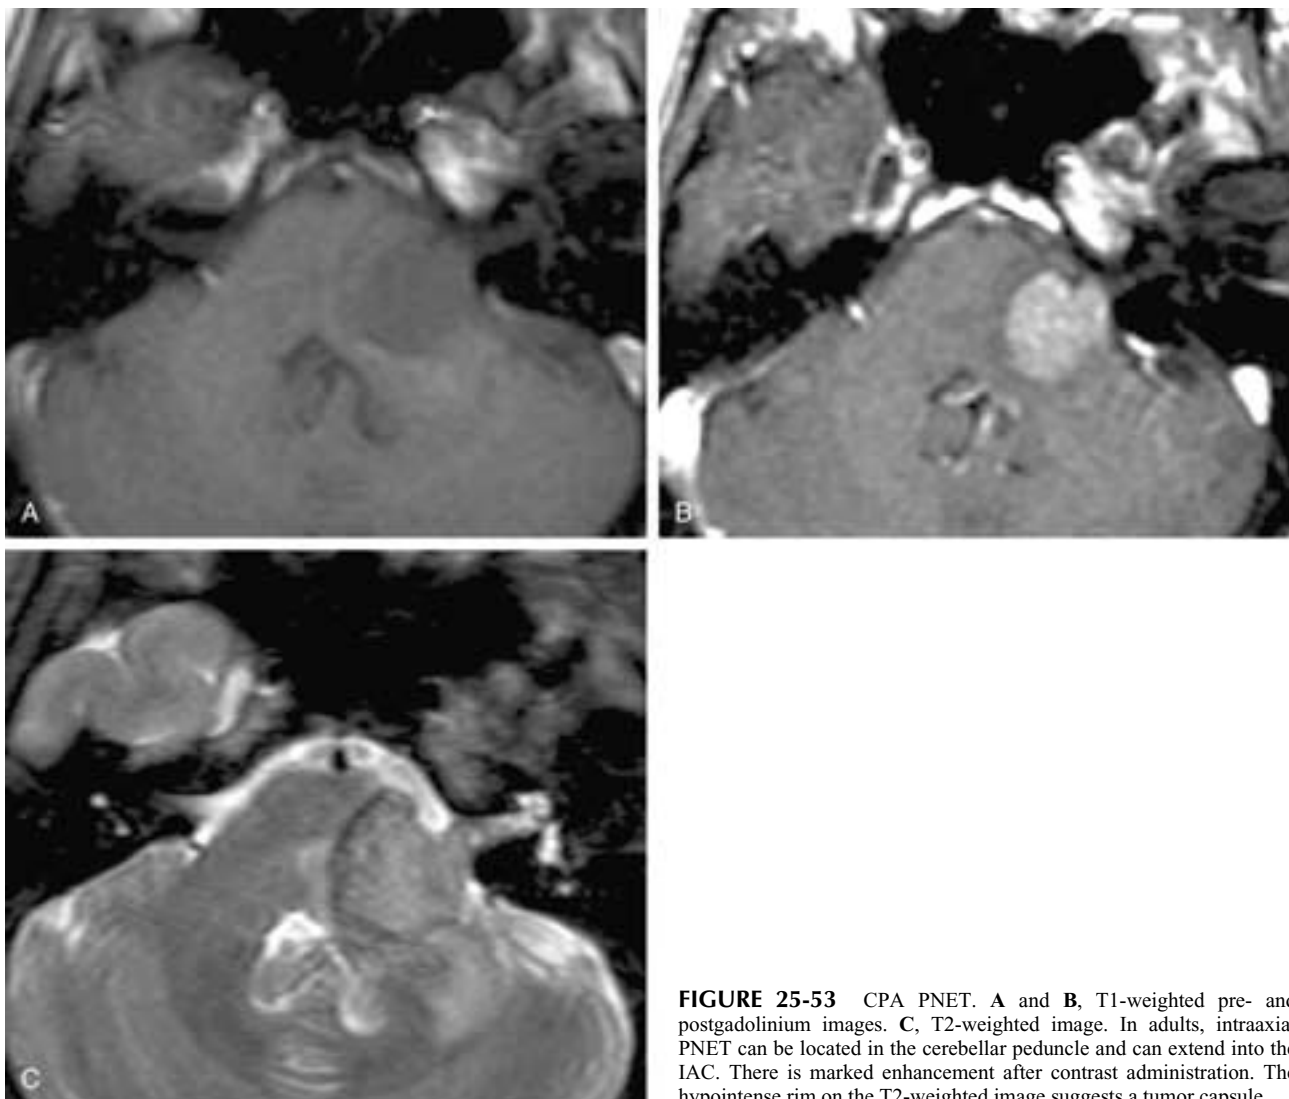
CPA PNET. A and B, T1-weighted pre- and postgadolinium images. C, T2-weighted image. In adults, intraaxial PNET can be located in the cerebellar peduncle and can extend into the IAC. There is marked enhancement after contrast administration. The hypointense rim on the T2-weighted image suggests a tumor capsule.
